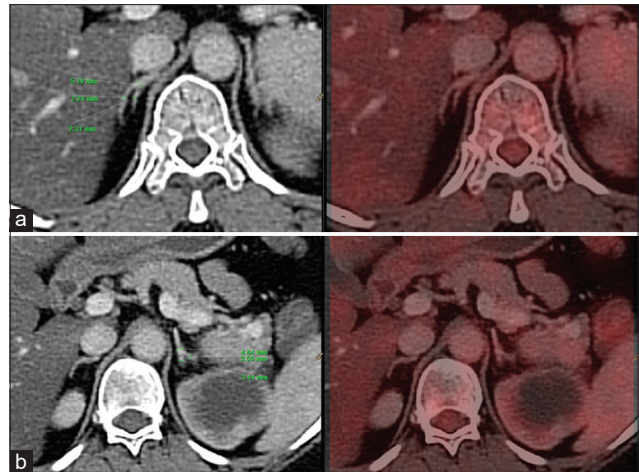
Normal. Computed tomography (CT) and corresponding positron emission tomography/CT images showing metabolically inactive normal appearing bilateral adrenal glands. CT images also demonstrating the measurements of both adrenal glands (a [right] and b [left]), i.e., maximum width of the body and both limbs
